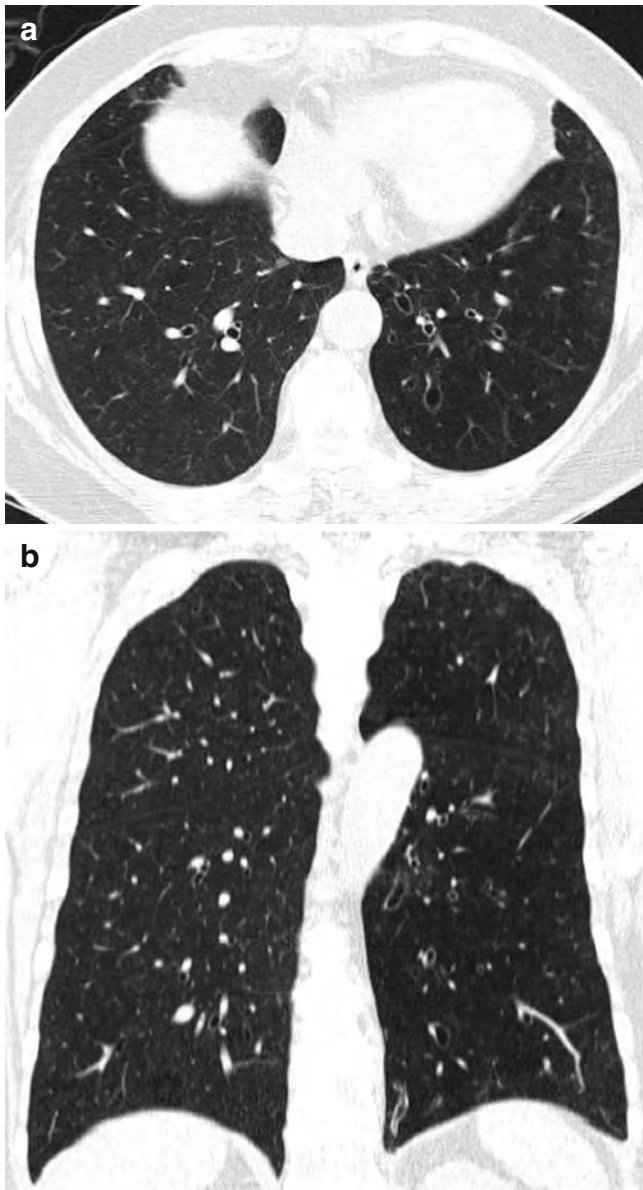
Swyer-James-MacLeod syndrome in a 71-year-old woman. (a) Lung window images of CT scans (2.5-mm section thickness) obtained at level of liver dome show bronchiectasis in left lower lobe. Also note mosaic attenuation in bronchiectatic left lower lobe. (b) Coronal reformatted image (2.0-mm section thickness) demonstrates bronchiectasis exclusively in left lung. Also note decreased lung attenuation in left lung
